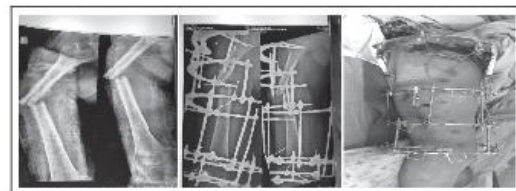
Pre-operative x-ray of thigh (R/V)
